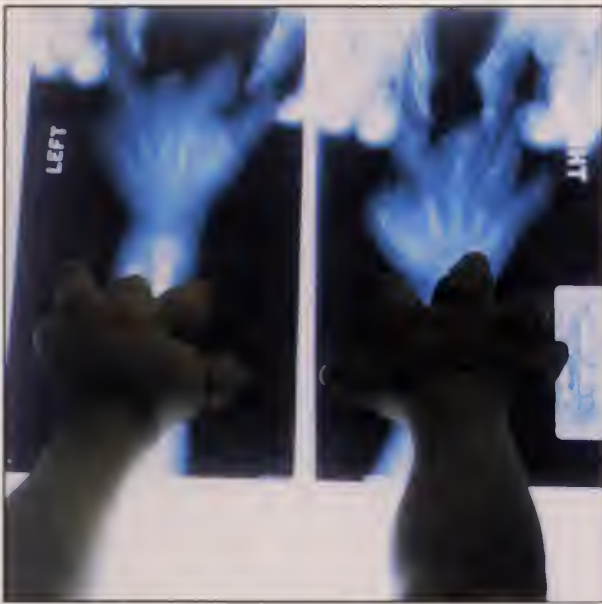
Photograph of hands, and AP views of hand and wrist, bilateral, of an eight-year-old child. At age four and a half months, she had been left in the snow at minus thirty-seven degrees F. (-38 deg.C). The baby had a core temperature less than 70 degrees.F, and sustained severe freezing of hands and feet. She was successfully warmed in water. She suffered severe hypermobility of joints, intrinsic muscle degeneration. The x-ray reveals absence of the carpals, and digital epiphyseal necrosis, with phalangeal shortening. An arthrogram of the wrists demonstrated total absence of cartilage as well as bone.
